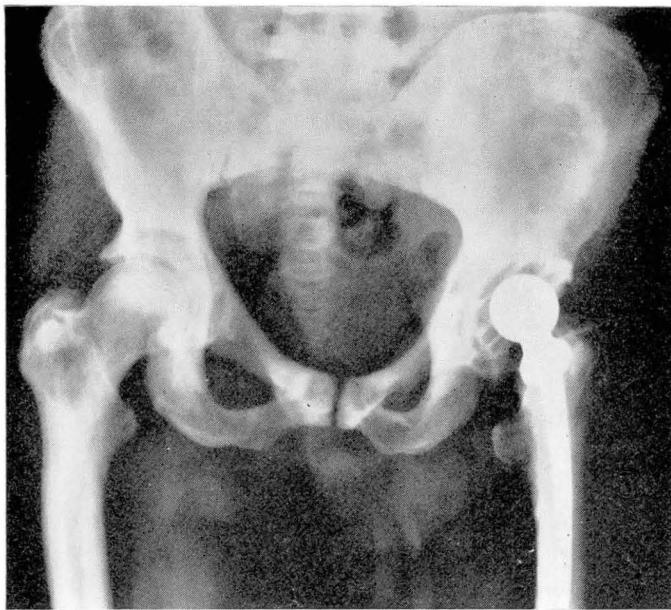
Roentgenogram showing the Charnley Muller total hip prosthesis in place. Note the fracture of the lesser trochanter.
